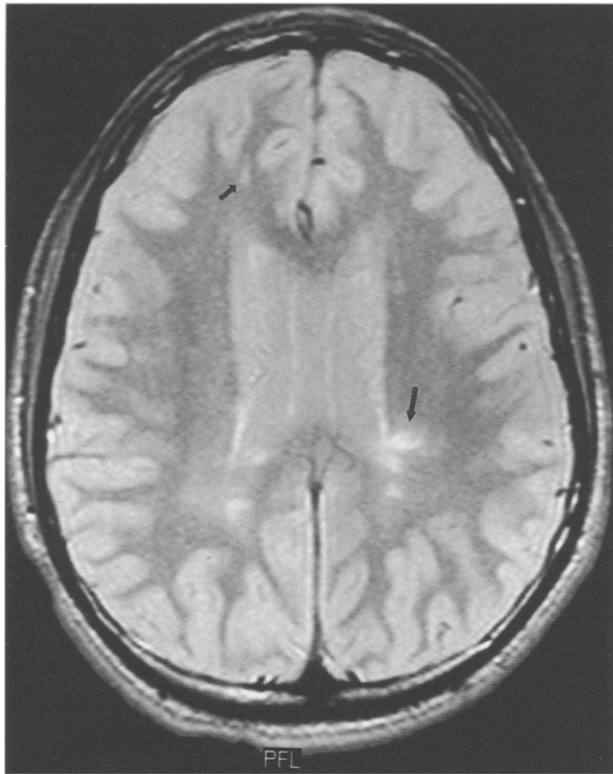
Multiple MRI signal abnormalities in the periventricular white matter. An axial proton density-weighted image demonstrates that some lesions (long arrow) are ovoid, with their major axes perpendicular to the ventricular margin. A subcortical white matter lesion (short arrow) is also evident.
